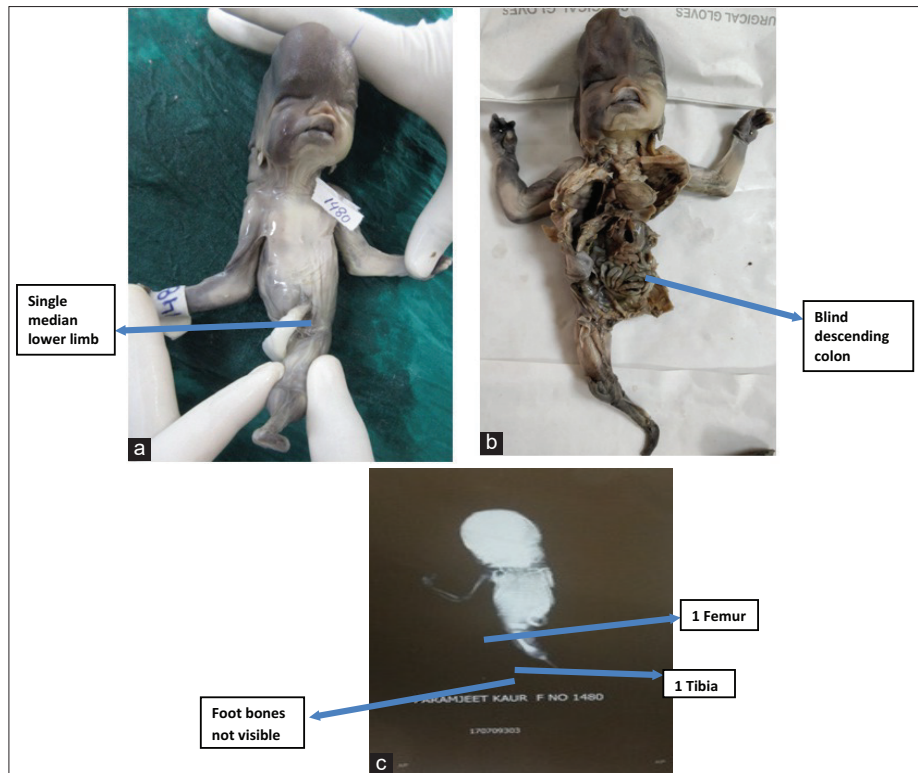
Case II - (a and b) External as well as internal examination of fused limbs. (c) showing X-Ray of fused limbs
